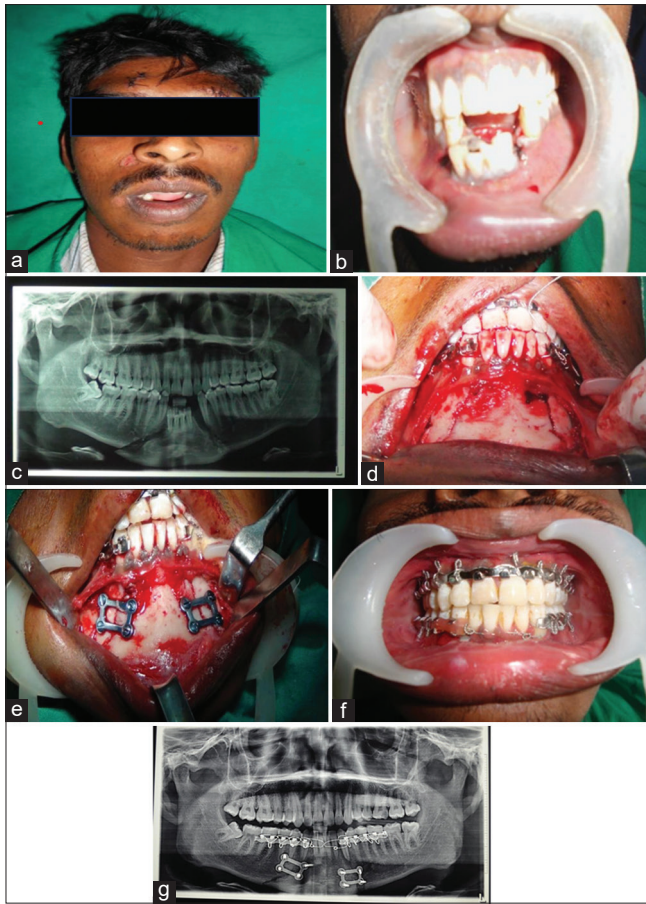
(a) Pre-operative profile of bilateral symphysis fracture. (b) Pre-operative occlusion. (c) Pre-operative radiograph bilateral parasymphysis fracture. (d) Fracture site exposed. (e) Fracture fixation with 3D titanium plates. (f) Post-operative profile and occlusion. (g) Post-operative radiograph
